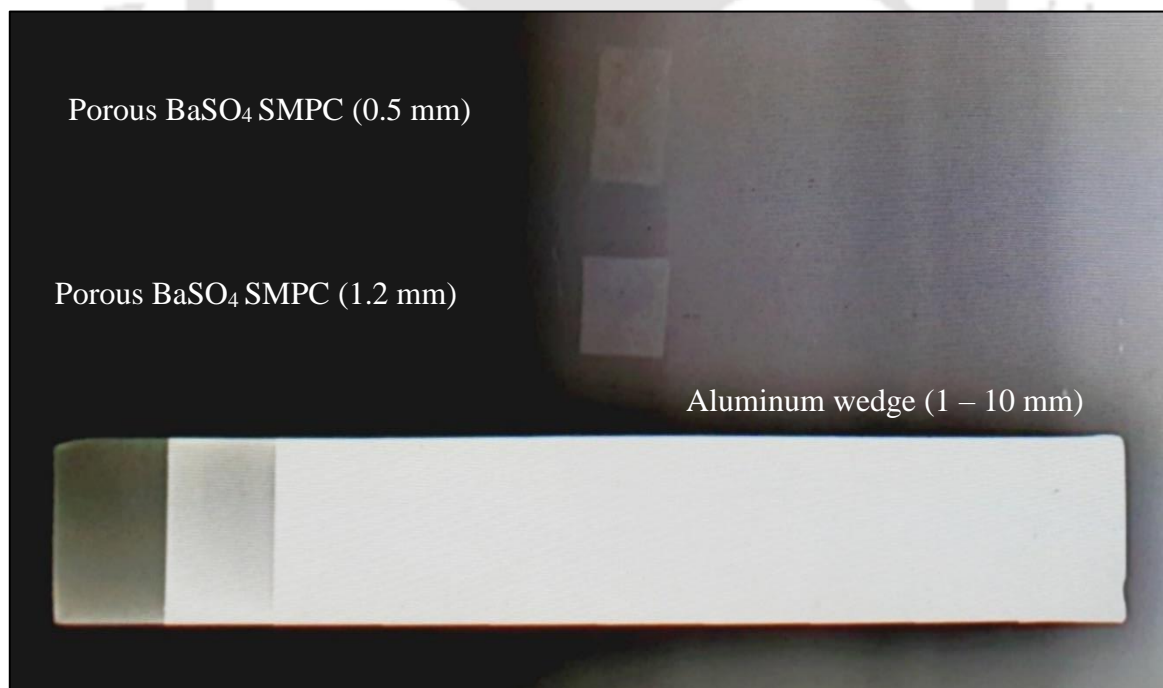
X-ray image of the porous BaSO₄ SMPC with an Aluminium wedge (1-10mm) as standard
